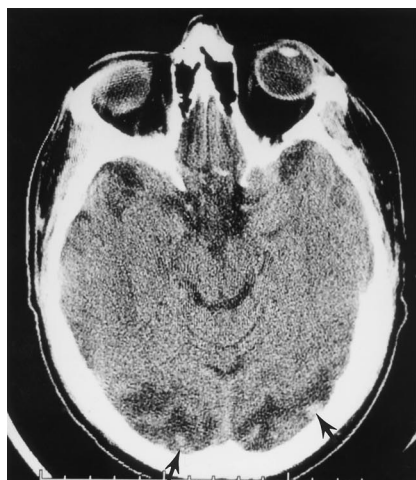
Patient 3: 12 days after transplantation. Axial noncontrast CT scan shows characteristic bioccipital hypodensity. Also seen is minimal cortical hemorrhage (arrows).
